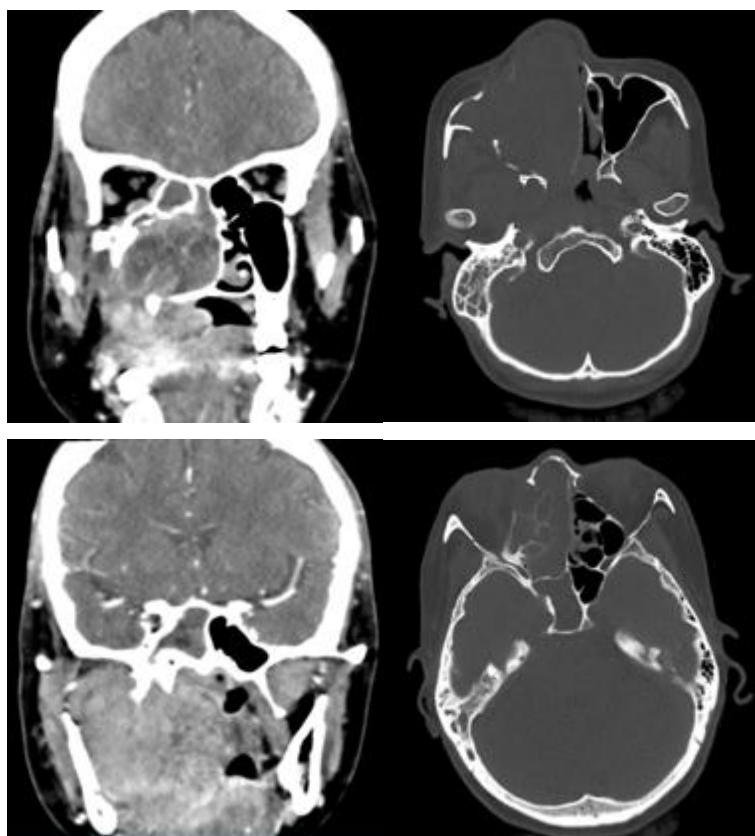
CT scan of the head, focusing on the paranasal sinuses (axial; coronal planes with contrast).
